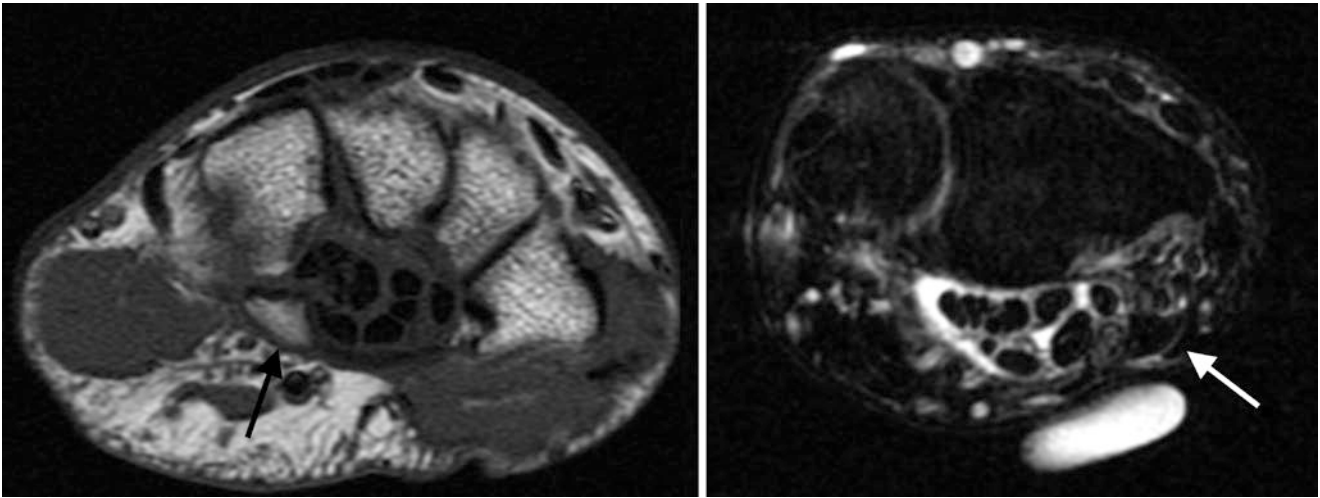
Axial MR images demonstrate a mildly displaced fracture of hook of hamate. Lack of edema like signal and corticated margins are suggestive of a chronic fracture
